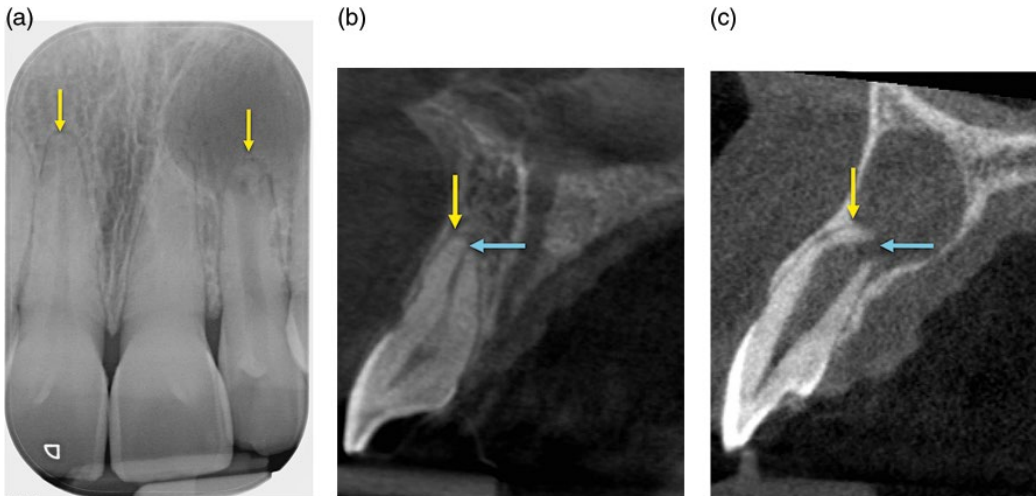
Apical periodontium. (a) Periapical radiograph of teeth 11, 21 and 22. The yellow arrows indicate the position of the radiographic apices of teeth 11 and 22, note the large periapical radiolucency associated with the 22. (b, c) Sagittal CBCT views of (b) tooth 11 and (c) tooth 22. The yellow arrows indicate the position of the most apical point of the roots of the teeth, which would correspond with the radiographic apices on the conventional radiographs. The position of the apical foramina of the teeth (blue arrows) are located at a more coronal position.
